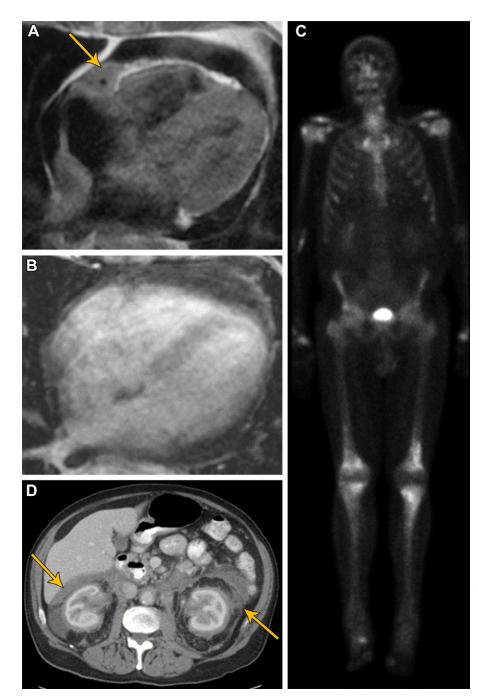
Encasement of the RCA in a 74-year-old man with Erdheim-Chester disease. (A, B) Four-chamber cardiac MR images show T2 intermediate signal intensity with a preserved RCA flow void (arrow in A) on the double inversion-recovery image (A), with homogeneous enhancement on the delayed gadolinium-enhanced image (B). (C) Methylene diphosphonate bone scan shows symmetric radiotracer uptake in the metadiaphyses of the bilateral femurs and tibias. (D) Axial contrast-enhanced CT image shows characteristic perirenal and retroperitoneal soft-tissue thickening (arrows).
